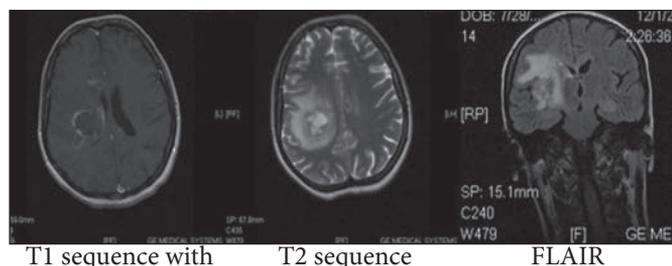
Brain MRI in a 27 year-old woman with AIDS and multiple brain lymphoma.
